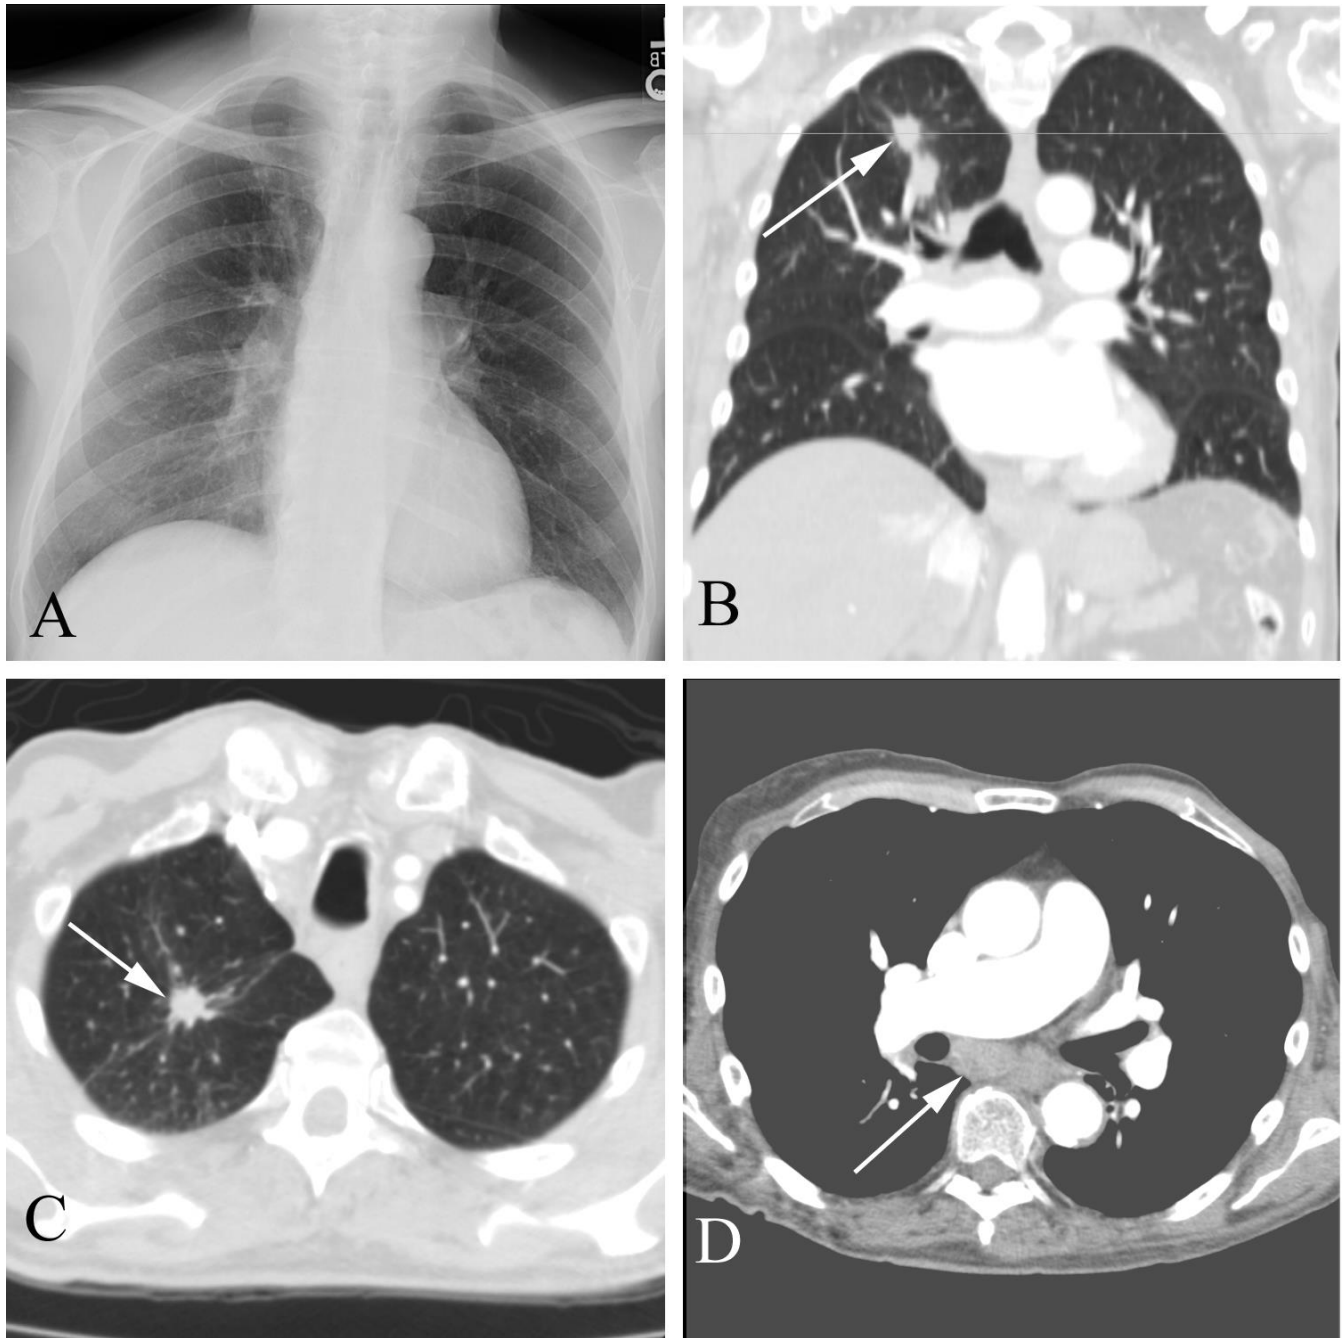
Metastatic disease in a 74 year old man with both breast and prostate cancer (!), with CT demonstrating lesions not seen on plain film examination. A. PA upright chest shows subtle, easily missed opacity in the medial right upper lung. B. Coronal reconstruction CT clearly shows a spiculated mass in the right upper lobe (arrow) along with an additional, more inferior lesion. Axial localizing line is at the plane of the axial slice in C. C. Axial CT also shows a spiculated mass. D. More inferior image shows bulky lymphadenopathy from metastatic deposit posterior to the right pulmonary artery (arrow).
